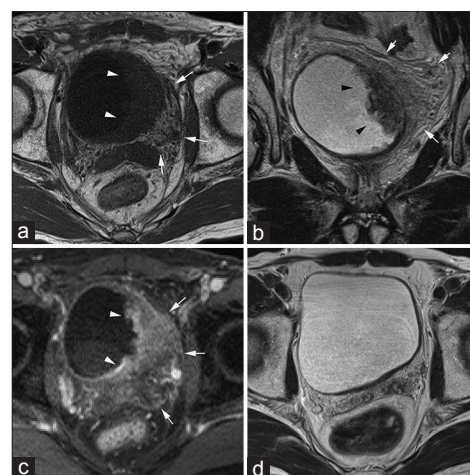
(a) On axial T1-weighted image, the irregular thickening of the bladder wall showing isointensity (arrowheads), and the stranding of a surrounding fat tissue is also seen (arrows) (b) On coronal T2-weighted image, the irregular thickening of the wall showing hypointensity (arrowheads). The stranding of a surrounding fat tissue is seen (arrows). The obliteration of the normal hypointensity of the muscle layer adjacent to the mass is also seen (c) The irregular thickening of the bladder wall showing a gradual and inhomogeneous enhancement (arrowheads) on equilibrium phase of the dynamic contrast study. The stranding of a surrounding fat tissue is also seen (arrows) (d) The both the irregular thickening of the bladder wall and the stranding of a surrounding adipose tissue was nearly disappeared on MR image without any treatment after three months
